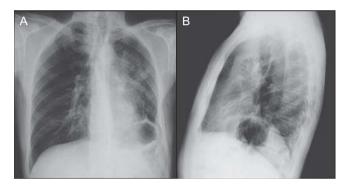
PA and left lateral chest X-ray on admission.
